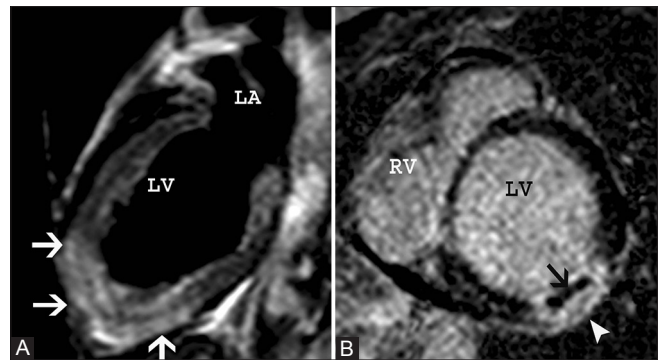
(A,B): Myocardial infarction. (A) Acute myocardial edema; the two-chamber T2-weighted black-blood image shows high signal in the apical anterior, apical inferior, and apical segments (arrows), consistent with myocardial edema in a patient with acute myocardial infarction. (B) Short-axis delayed-enhancement image shows a dark non-enhancing area (arrow) in the basal infero-lateral segment within a focal area of enhancing myocardial scar (arrowhead), consistent with microvascular obstruction within an acute myocardial infarction
